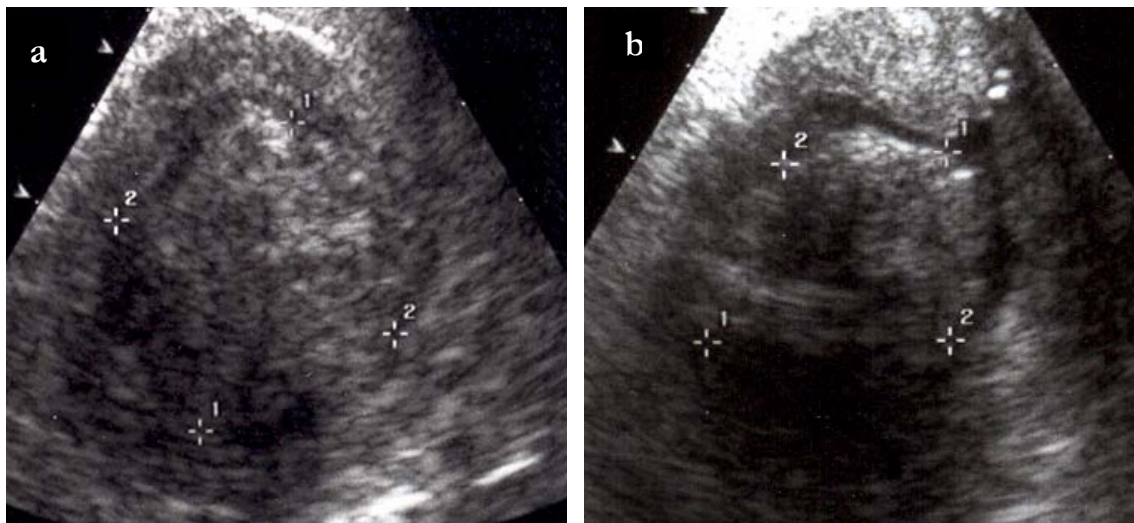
(a) submucous myoma at conventional ultrasound; (b) submucous myoma at hydrosoneography
